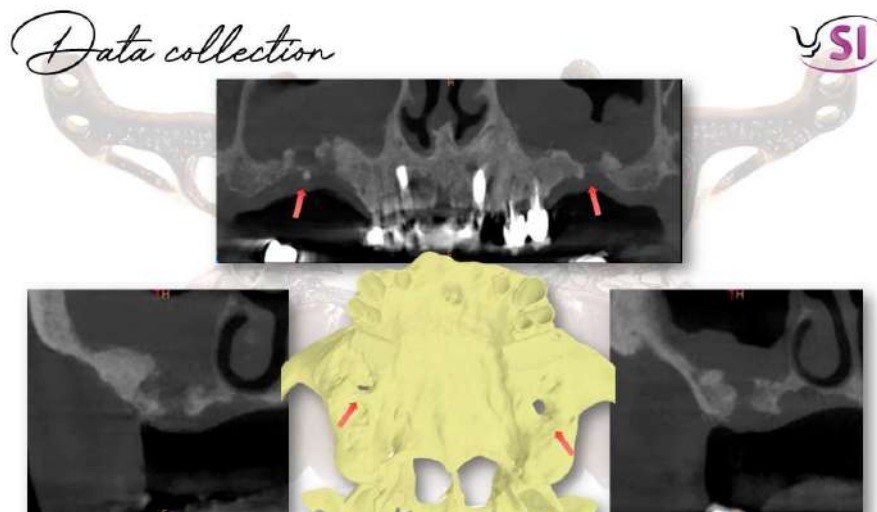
CBCT data collection. Coronal and sagittal sections confirm bilateral oroantral communications (red arrows).
